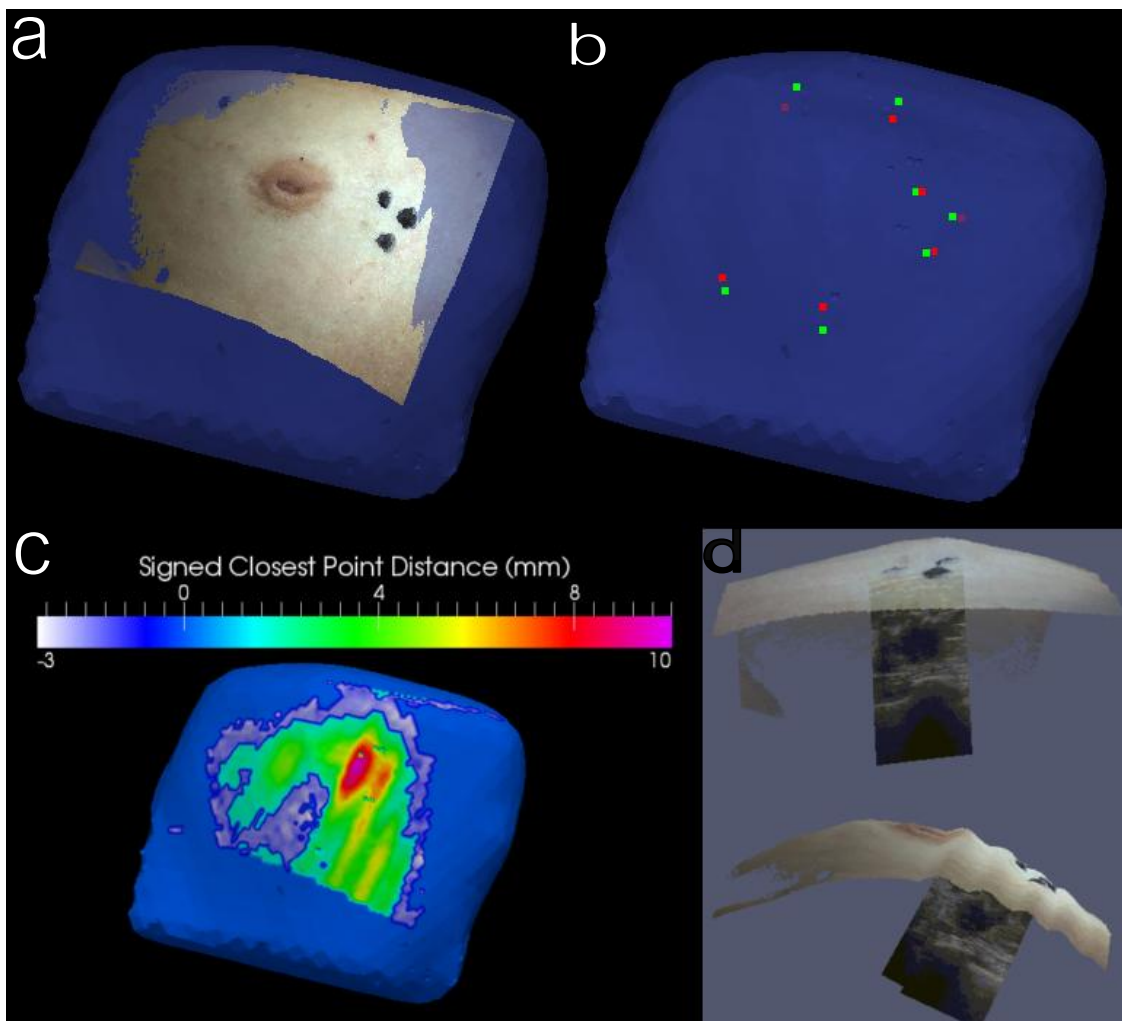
a) Registered digitized breast surface overlaid onto MR generated mesh. b) MR fiducial center points (green) with registered physical space fiducial center points (red) overlaid onto patient specific mesh. c) Signed closest point distance map between laser range scanner point cloud and mesh surface nodes. d) Two orthogonal views of a textured point cloud of the breast with calibrated ultrasound slices showing tumor location in physical space.
